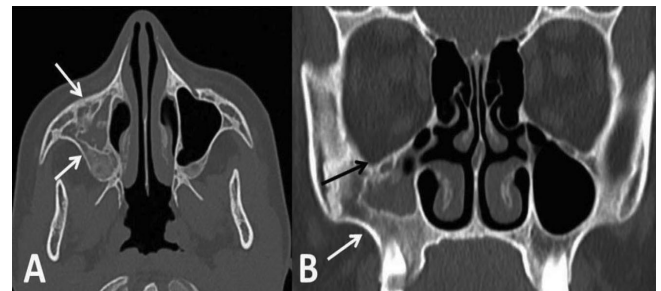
Axial and coronal CT of paranasal sinuses showing a small right maxillary sinus with convex outer walls (A and B white arrow) and inferior margin of the right orbit slightly lower than that of the left orbit.
